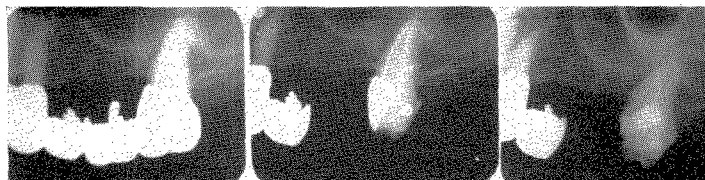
Roentgenograms of the removal of the posterior section and the final repair. The patient at this time was 75 years old.
